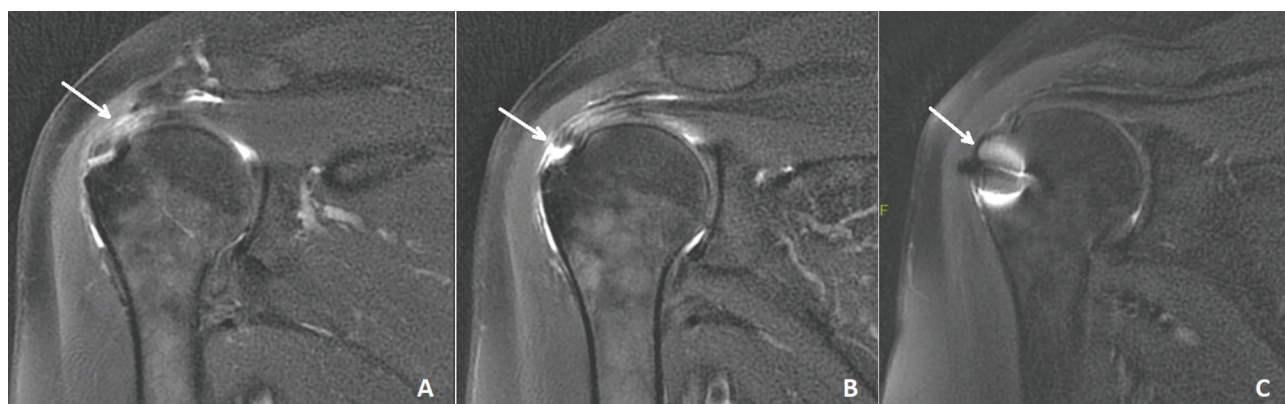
A) Coronal T2 MRI image of a 53-year-old male patient who was interpreted as the presence of supraspinatus and infraspinatus tendinitis in the right shoulder (arrow: tendon attachment site); B) another coronal T2 section of the same patient, a full-thickness tear was detected in this patient's operation, and it was repaired (arrow: tendon attachment site); C) postoperative 12th month MRI image (arrow: tendon attachment site of the repaired tendon).
